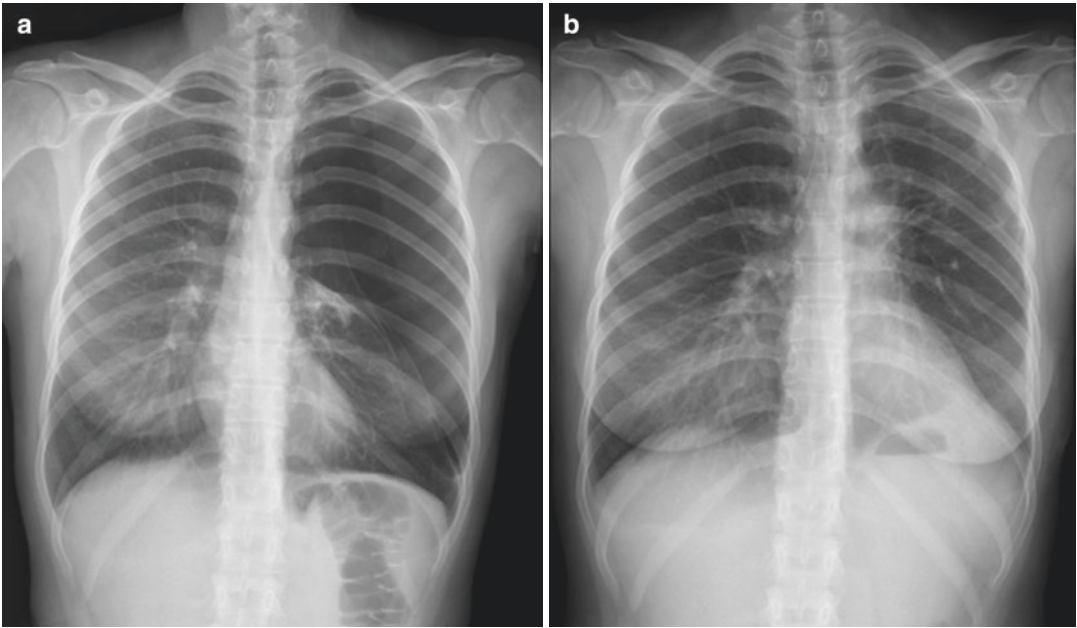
(a) A giant bulla is seen in the preoperative chest X-ray of a young female patient, (b) postoperative chest X-ray of the same patient shows re-expansion of the lung
